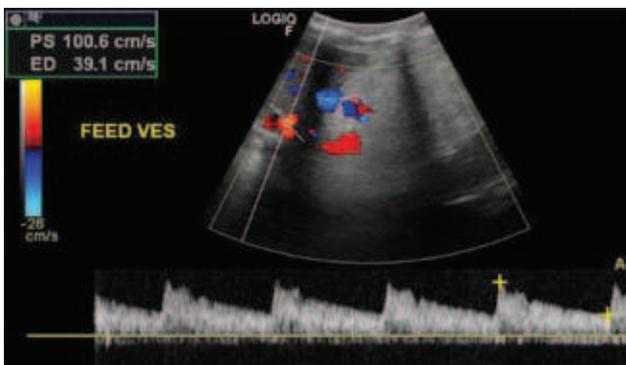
Color Doppler ultrasound (US) image that shows a feeding vessel of the lesion.
